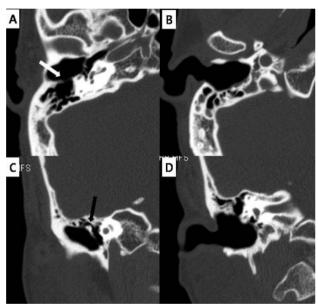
Temporal bone computed tomography. Axial view; A: Destruction of the posterosuperior bony external auditory canal (white arrow). B: Coronal view of a widened bony external auditory canal with partial exteriorization of mastoid air cells. Coronal view; C: Intact malleus head with shallow epitympanum (black arrow). D: Widened bony auditory canal with partial exteriorization of mastoid air cells.
